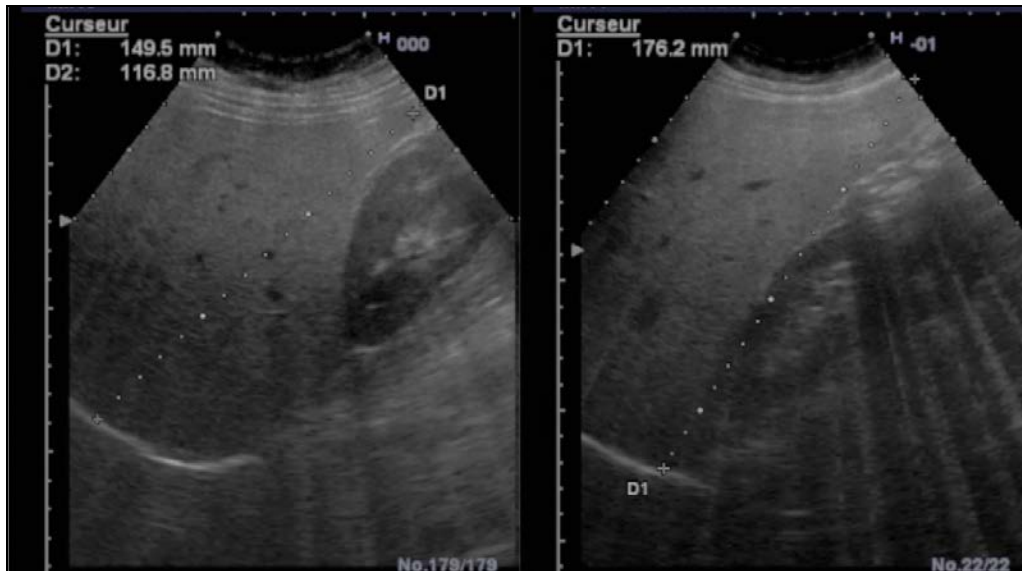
Longitudinal ultrasound sections of the liver showing an increase in hepatorenal echogenicity gradient without deep ultrasound attenuation in favor of moderate steatosis
